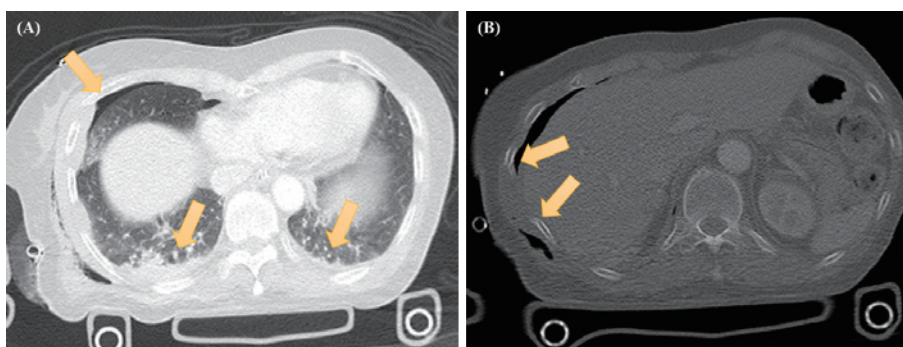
Findings of thoracic CT scanning.
